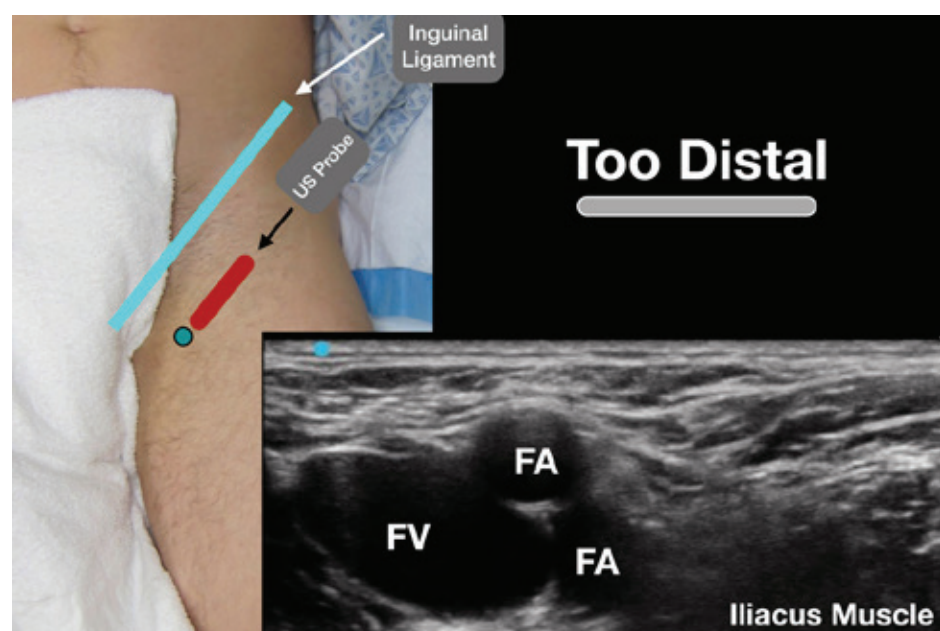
Error 1: The ultrasound probe is too distal in the thigh. The femoral artery has split into the deep and superficial femoral arteries, making visualization of the fascia iliaca and iliacus muscle difficult.
